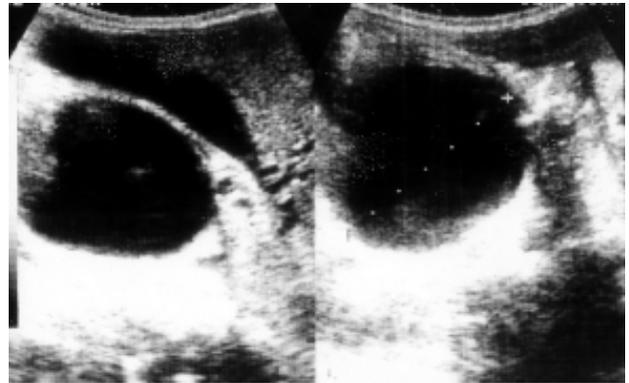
Abdominal ultrasonography showed intrahepatic biliary ductal dilatation and cystic dilatation of choledochus
